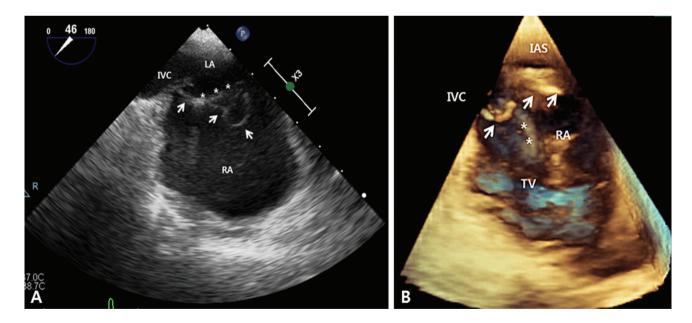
(A) Two-dimensional transesophageal echocardiography (TEE) imaging does not clearly show the location of the Chiari network (arrow) in relation to the pulmonary artery catheter (PAC, *) (B) Three-dimensional TEE imaging shows that the PAC(*) successfully passed through the tricuspid valve without being entrapped in the Chiari network (arrow). IAS: interatrial septum; IVC: inferior vena cava; LA: left atrium; RA: right atrium; TV: tricuspid valve.
